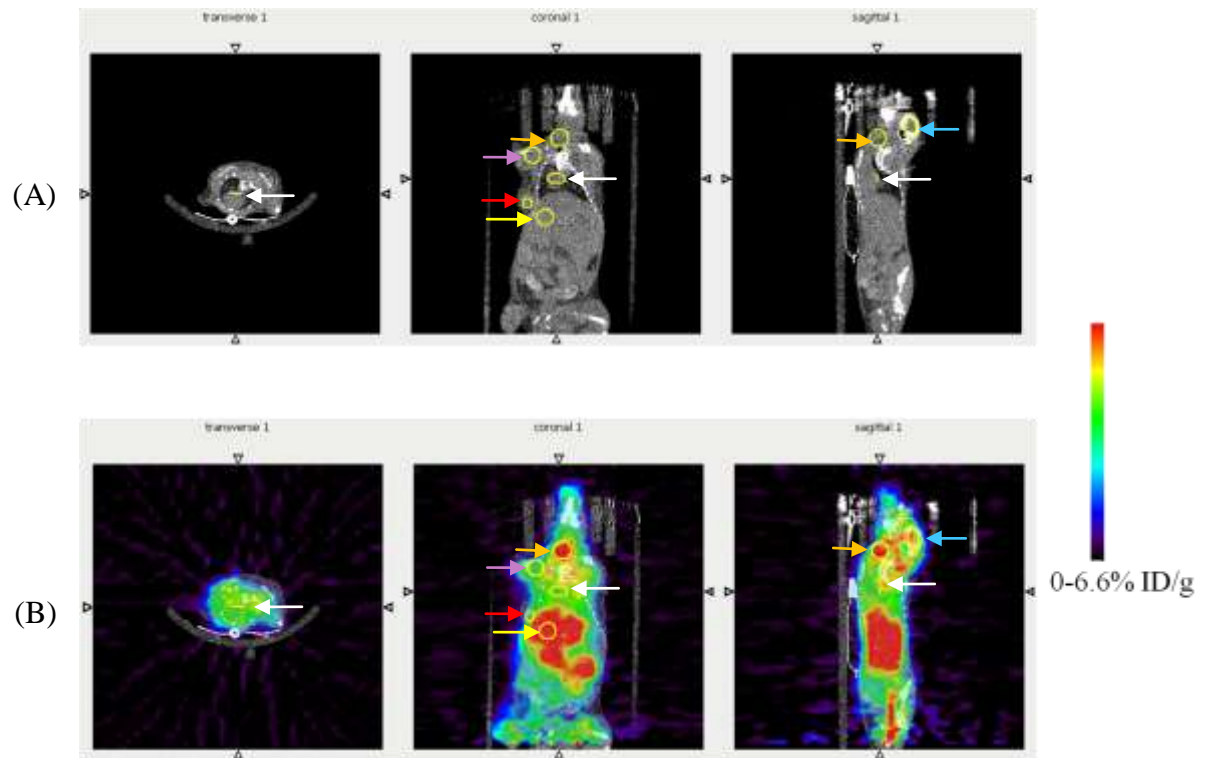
Dynamic PET image 6-7 minute pi: ROIs for tumour (coronal view; red arrow), liver (coronal view; yellow arrow), throat (coronal and sagittal view; orange arrow), front leg muscle (coronal view; purple arrow) and heart (transverse, coronal and sagittal view, white arrow). (A) CT image (B) PET/CT image. PET colour indicating 0-6.6% ID/g
